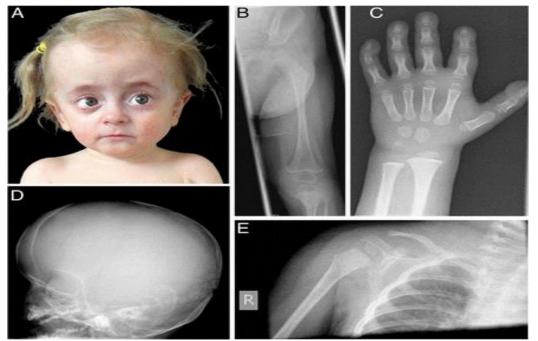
7- Her radiographs. A-Facial dysmorphism at two years; B-delay in epiphyseal maturation and thin long tubular bones at 15 months; C-retarded maturation of phalanges, carpals, and metacarpals at three years and two months; D-Skull at 15 months, Hypoplastic maxilla, large fontanels, and poor ossification of calvarium; E-Epiphyseal delay of the right shoulder at 13 months. (24)
